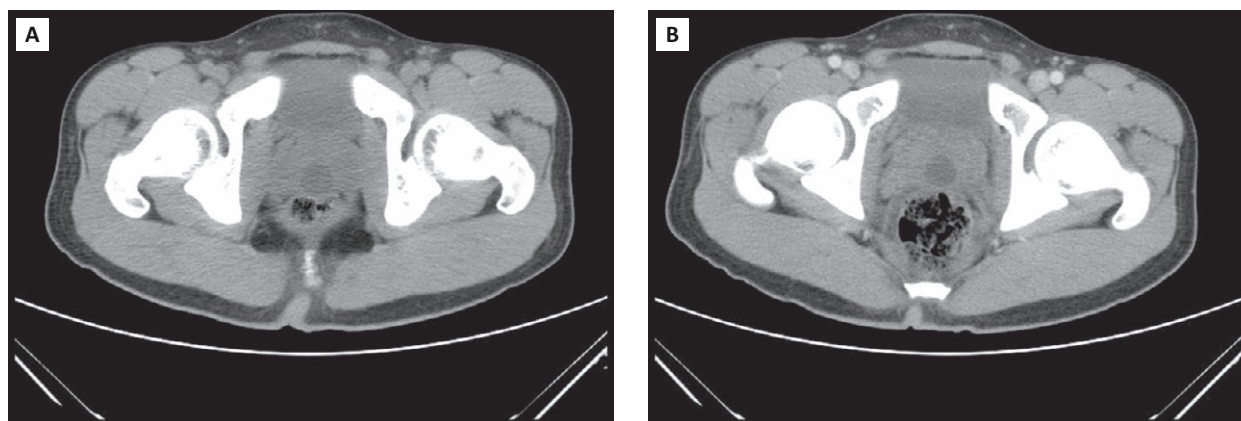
Abdominal computed tomogram showing a low-density cystic component lesion in the central zone of the prostate with focal peripheral enhancement: (A) before enhancement and (B) after enhancement.
